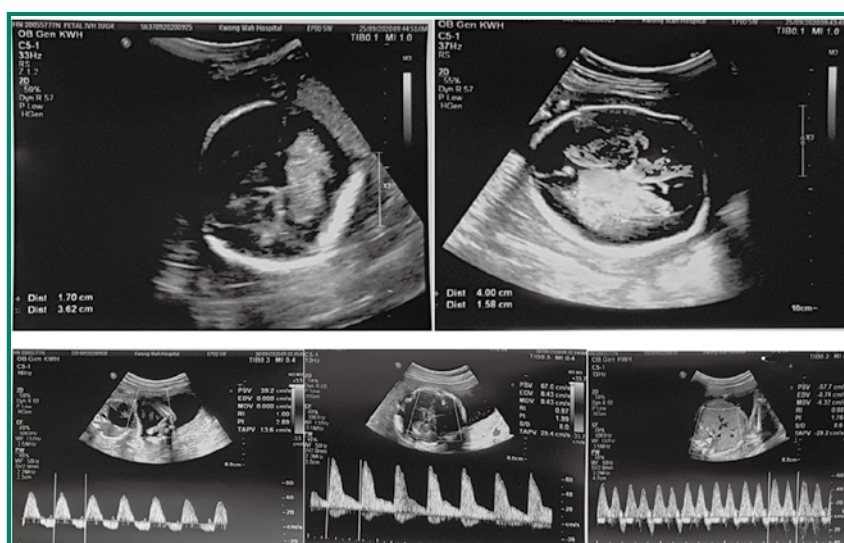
Ultrasound showing foetal intraventricular haemorrhage and abnormal Doppler ultrasound (27 weeks' gestation) (Photos from the personal collection of the first author WC Leung)
